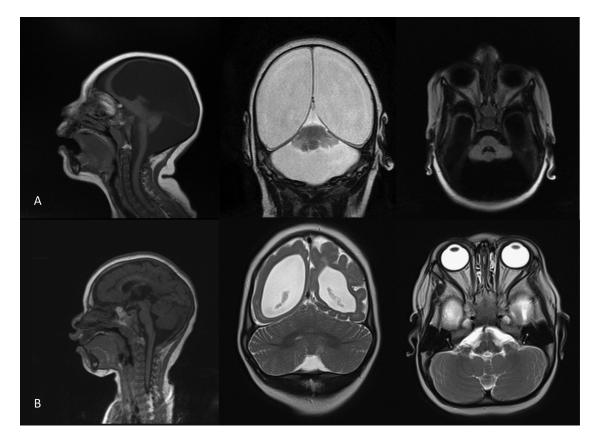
Magnetic resonance imaging of 2 children with congenital Zika syndrome (from left to right sagittal, coronal, and transversal views). (A) Severe infratentorial abnormality (severe hypoplasia of cerebellum, vermis cerebelli, and brainstem). (B) Absence of severe infratentorial abnormality.
